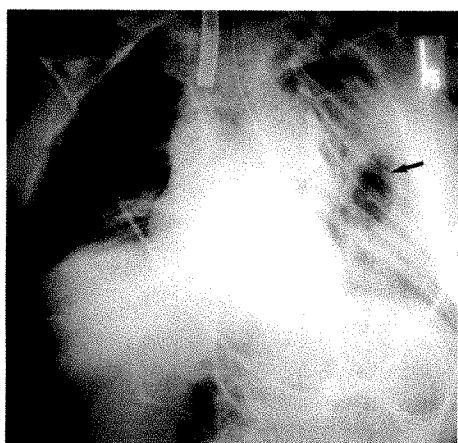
Chest roentgenogram taken after reexpansion of the pneumothorax. Note the persistent ovoid lucency in the left mid-lung field (arrow), characteristic of a lung laceration.
